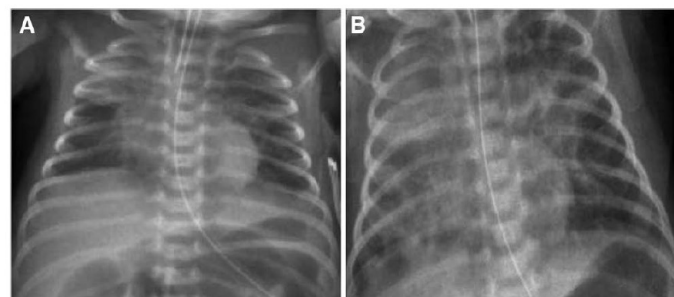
Chest radiograph of the 24+6 gestational age neonate with evolving ventilator-associated pneumonia at (A) day 18: right upper lobe collapse (B) day 20: consolidation over the entire right lung.
